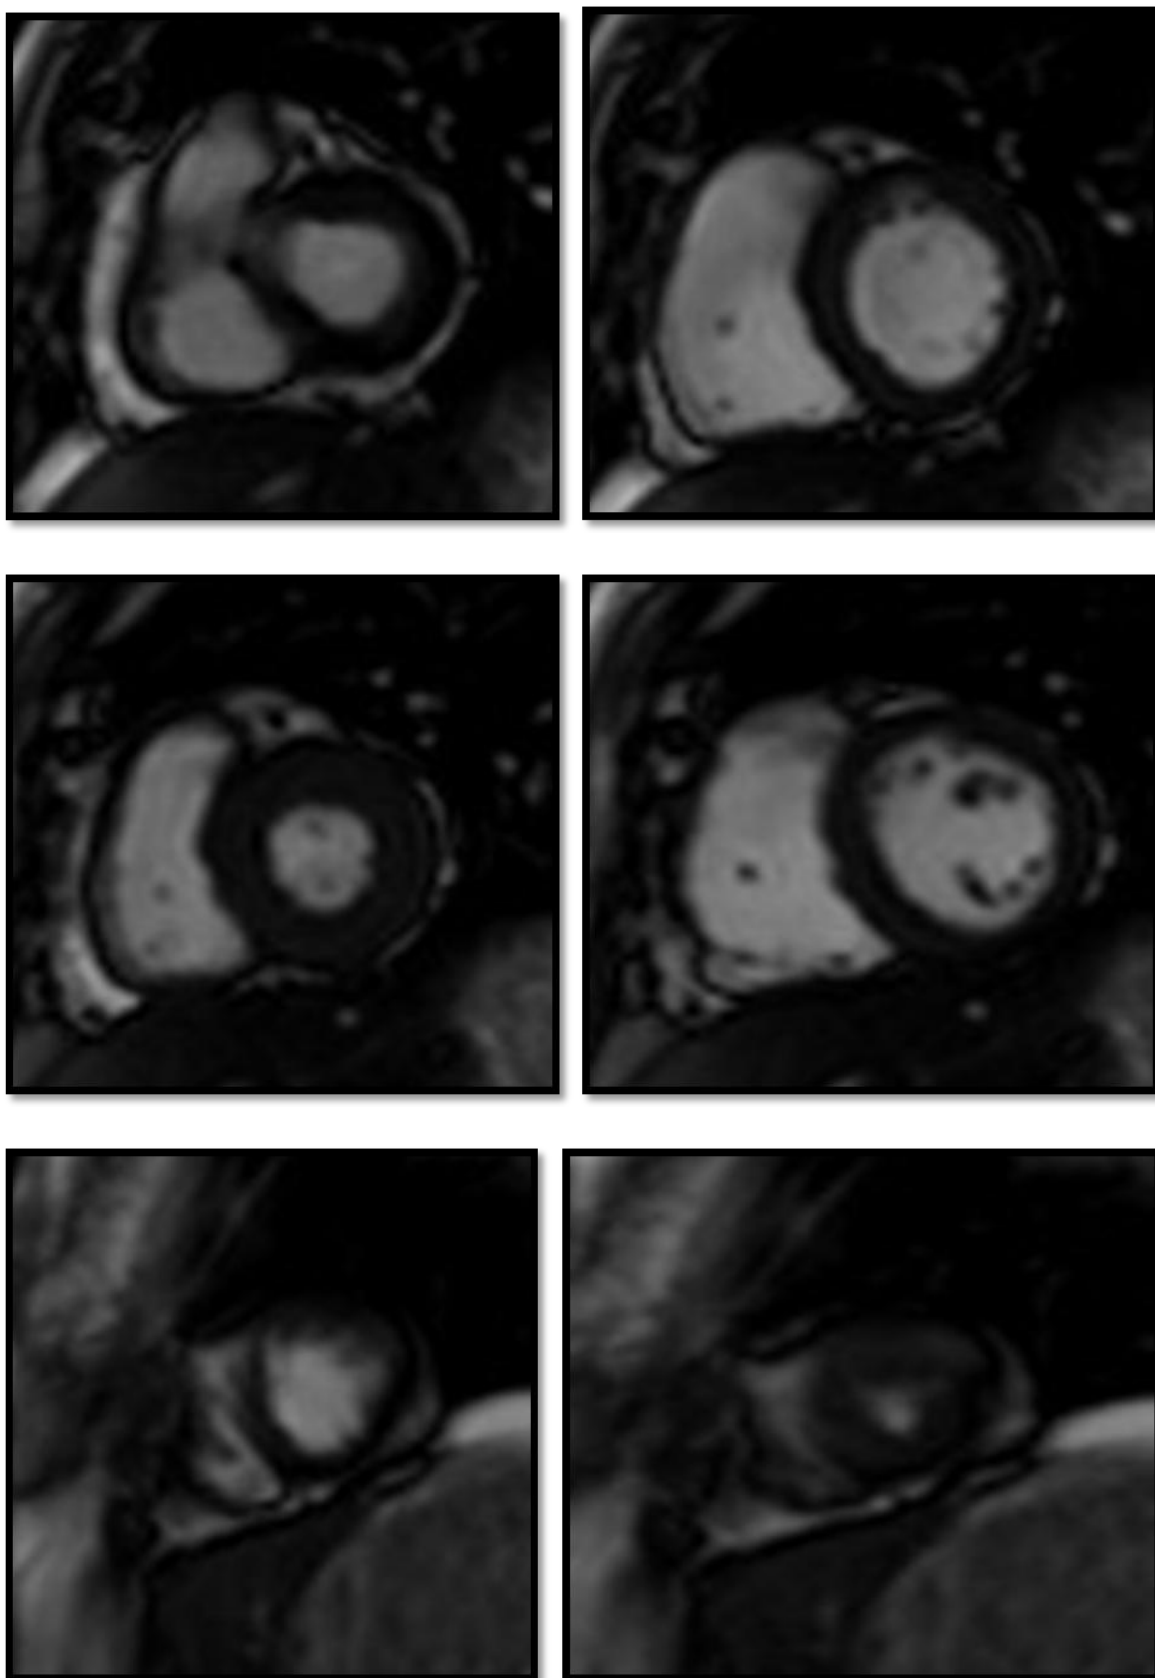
MRI CINE short axis at systole and diastole at basal, mid-cavity and apical levels
